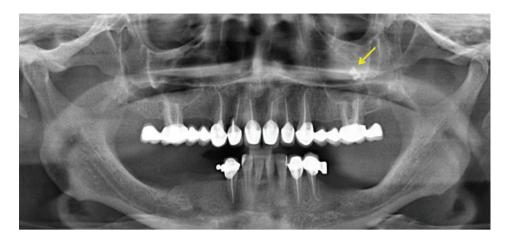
Panoramic radiograph shows a radiopaque mass in the left maxillary sinus.
